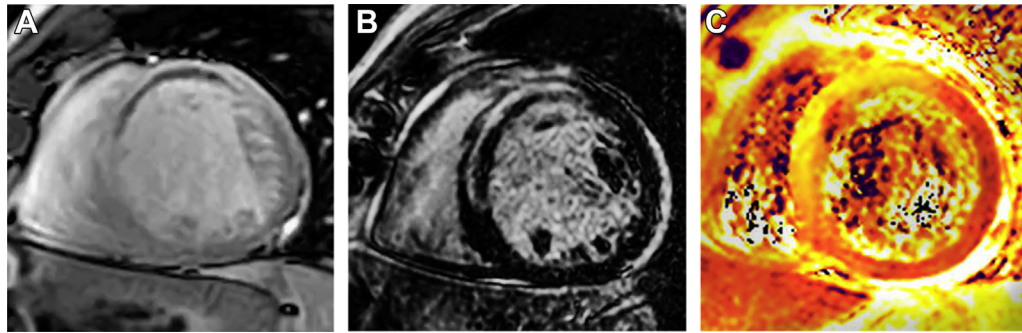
Cardiovascular magnetic resonance imaging in acute myocardial infarction. Male patient over 12 h after onset of chest pain with ST-elevation myocardial infarction. Cine CMR imaging after contrast administration (only mid slice of a whole heart short-axis stack shown) shows low signal in the subendocardial portion of the anterior and antero-septal segments—suggesting microvascular obstruction. (B) Late gadolinium enhanced images in corresponding short-axis orientation at mid ventricular level shows near-transmural contrast enhancement in the anterior and antero-septal segments with low signal in the subendocardial portion. This finding suggests microvascular obstruction. (C) T2 mapping in corresponding short-axis orientation shows high signal in the anterior and antero-septal segments consistent with myocardial edema.
